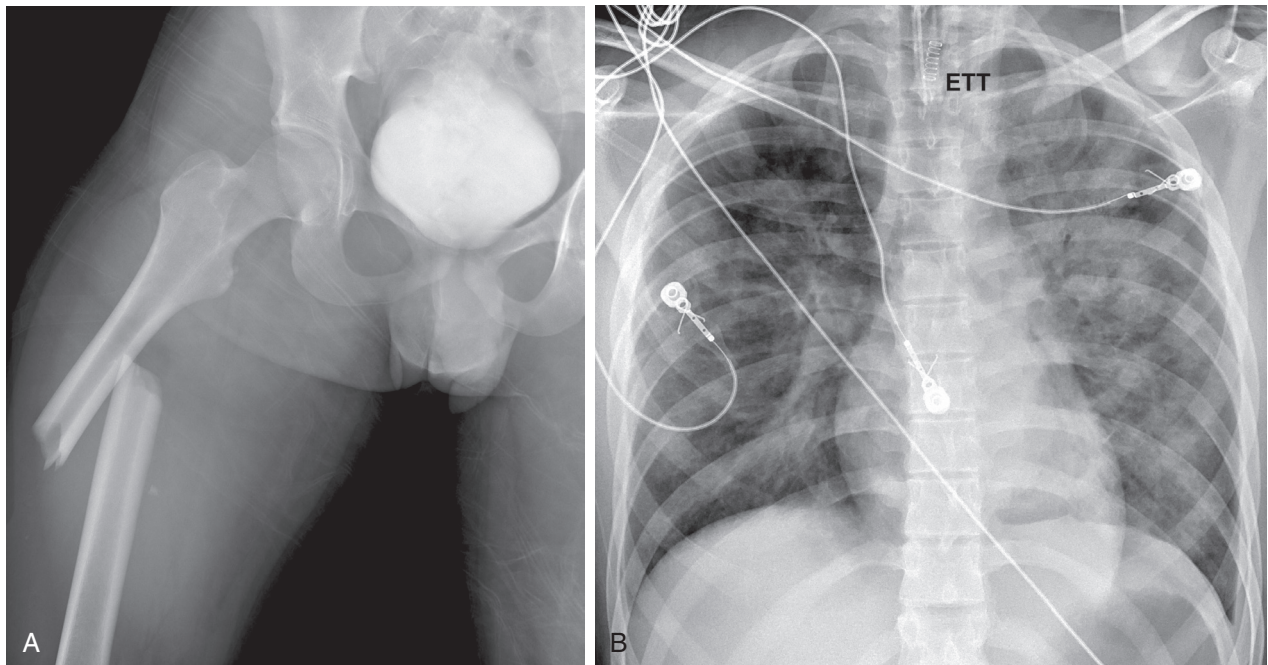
■ A, Anteroposterior (AP) supine right femur x-ray. Proximal right femoral shaft fracture. B, Anteroposterior (AP) upright chest x-ray. Chest x-ray of the same patient demonstrates diffuse bilateral airspace opacities due to fat emboli, developed approximately 24 hours after femur fracture. ETT, endotracheal tube in proper position.
